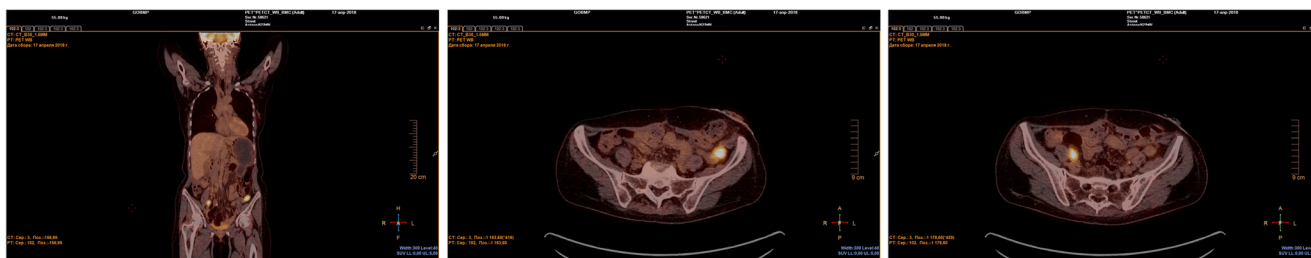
Results of PET/CT 21 October 2019
